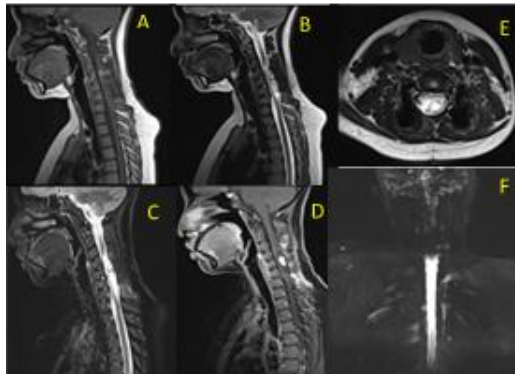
MRI whole spine sagittal and axial results show an intradural intramedullary lesion at the C5 level with syrinx intramedullary. (A) The lesions appear isointense to the spinal cord on T1WI, (B,C) slightly hyperintense on T2WI/STIR, (D, E) demonstrate strong homogeneous contrast enhancement. (F) Myelography MRI show partial obstruction at Cerebrospinal Fluid (CSF) flow.
